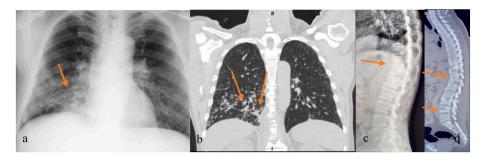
Chest X-ray with accentuated bilateral alveolar infiltrate in lung bases (a). Axial tomography of the chest showing nodular lesions with a tendency to consolidate in the right middle and lower lobes, pulmonary bronchiectasis, and right basal pleural thickening (b). Plain lateral radiograph of the lumbar spine with kyphosis and non-evident lesions (c). Tomographic with thoracolumbar kyphosis, punched-out lytic lesions (T9-L5), 50 % loss of bone mass at T10-T12 (d).
